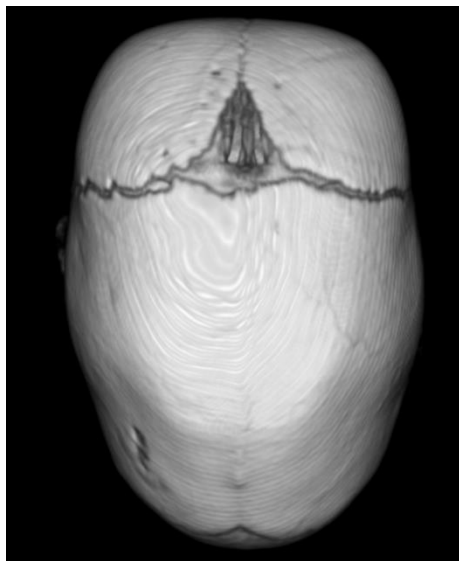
(Left) Preoperative CT scan showing sagittal synostosis. (Right) 1-year postoperative CT scan with neosuture formation.
